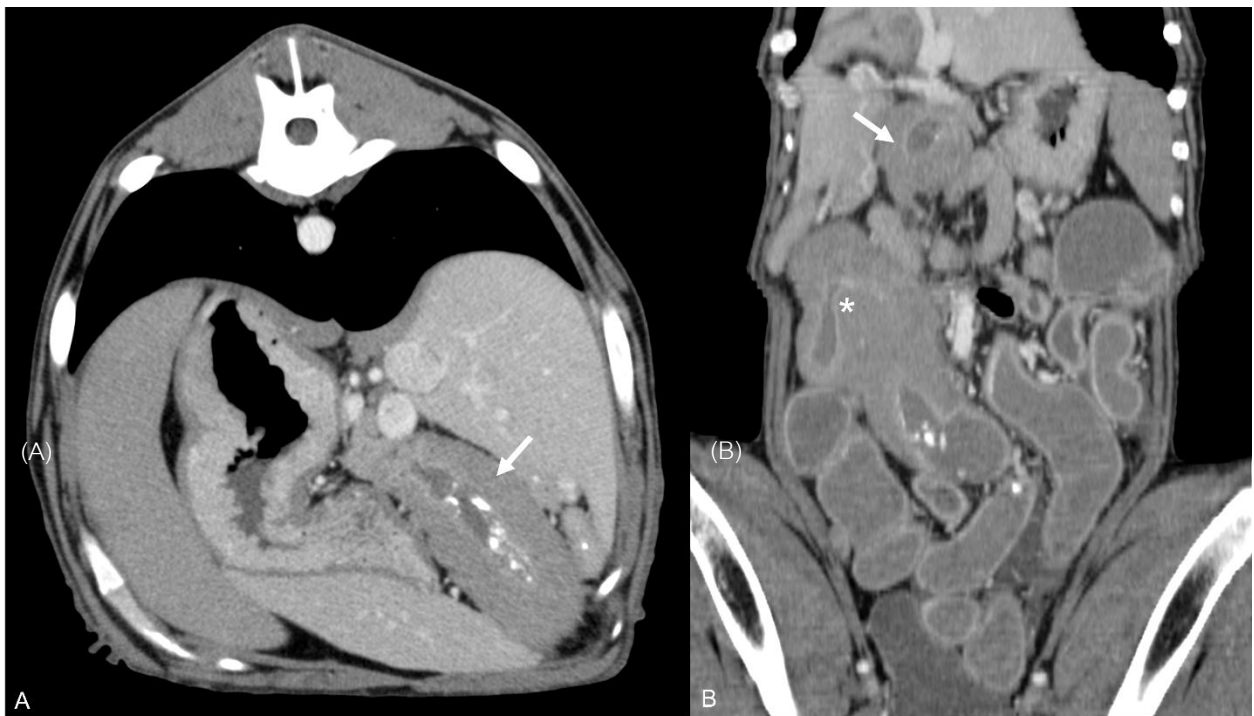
Transverse (A) and dorsal planes (B) of abdominal, contrast enhanced computed tomographic images showed conspicuous circumferential wall thickening of the ascending colon with homogeneous soft tissue attenuation (arrow) and luminal narrowing (asterisk).
